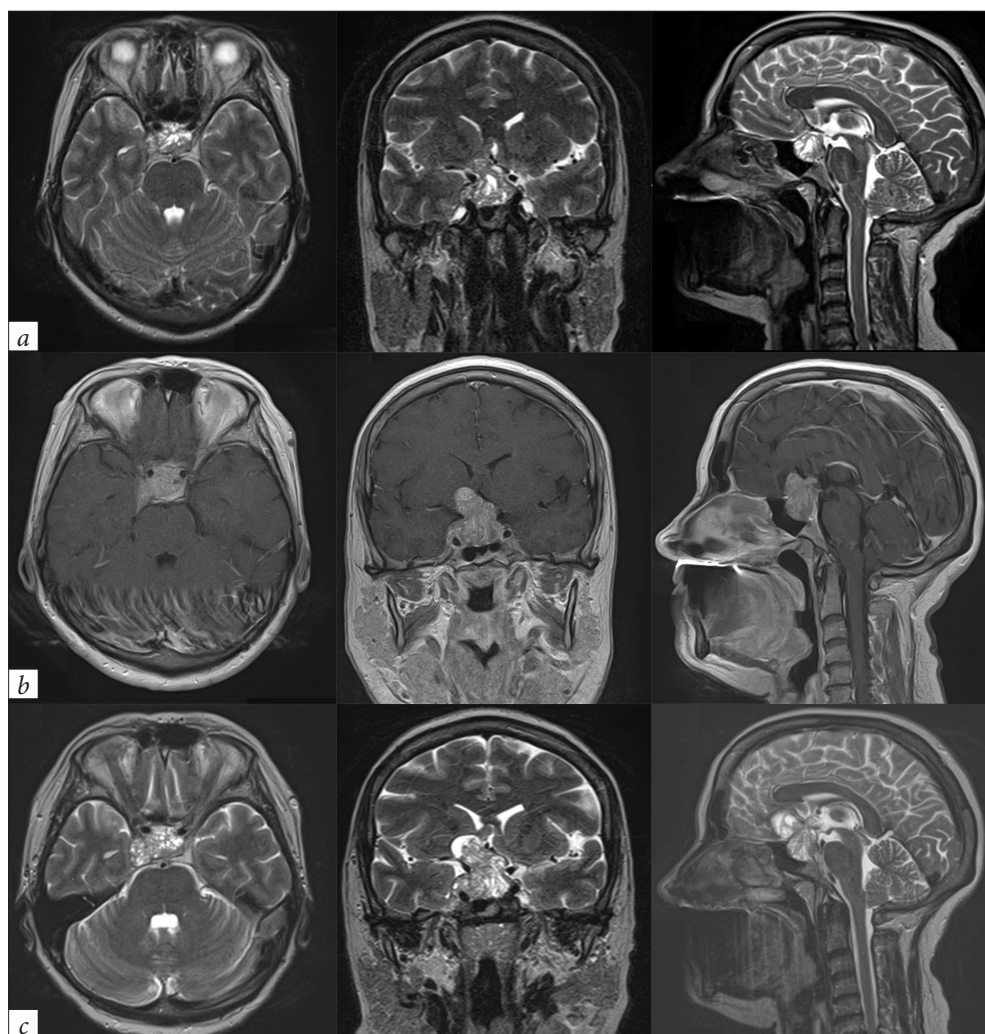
Series of axial, coronal, and sagittal MR images. (a) December 2015. Non-enhanced T2-weighted MRI showing a macroadenoma $25.8 \times 17 \times 21$ mm with asymmetric suprasellar extension and obvious compression of the optic chiasm and right cavernous sinus invasion up to 6 mm (III-a type, by Knosp et al.). Tumor has a heterogeneous structure due to areas of cystic change. (b) December 2016. Contrast-enhanced T1-weighted MRI. Compared to the previous survey, tumor increased in size up to $32 \times 21 \times 28$ mm. (c) December 2017. Non-enhanced T2-weighted MRI showing tumor progression up to $35 \times 32 \times 28$ mm, mostly due to the ante-suprasellar part
